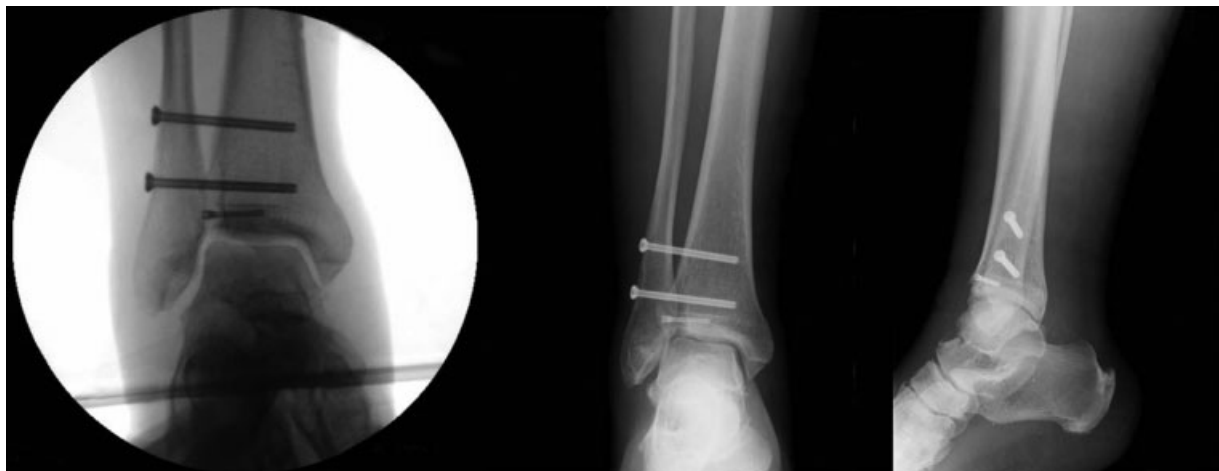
Intraoperative fluoroscopy control – left; Postoperative radiograph – right.
